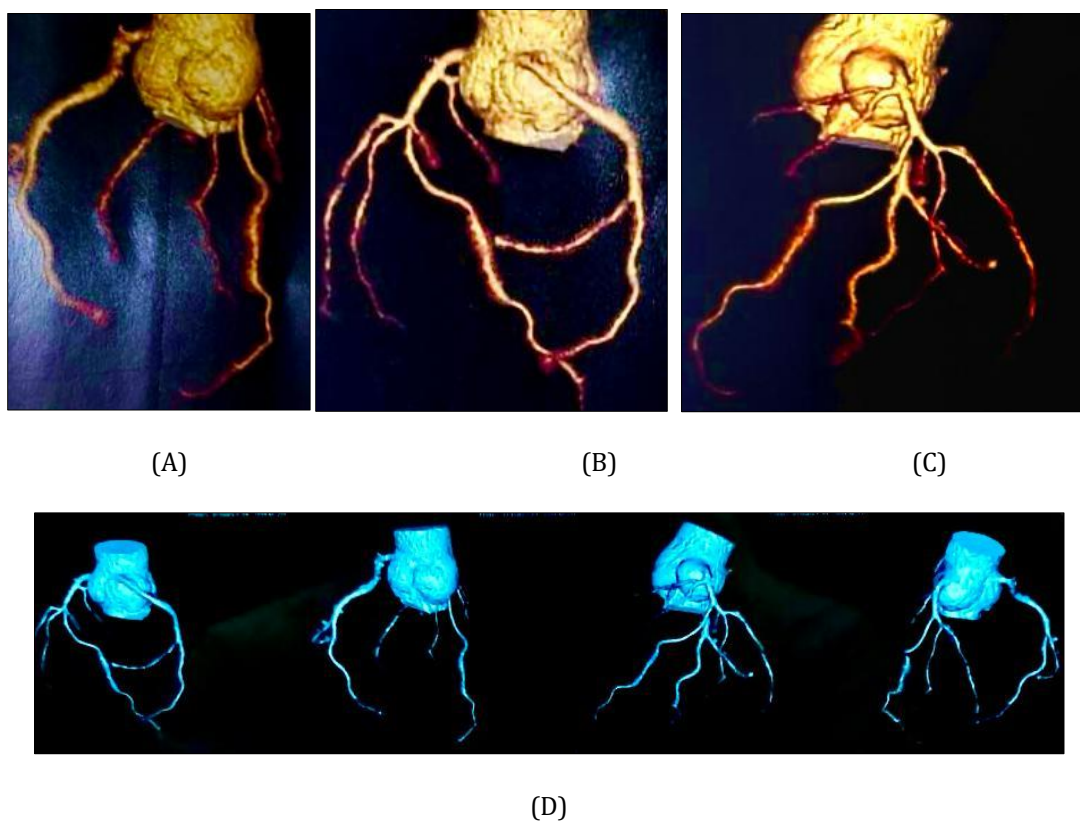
Coronary CT angiography. (A) Right coronary artery arising from left aortic sinus; (B) Left coronary artery arising from right aortic sinus and right coronary artery arising from left aortic sinus; (C) Left coronary artery arising from right aortic sinus; (D) Similar features of coronary anatomy in dextrocardia with situs inversus, as mentioned in figures 19 A-C
